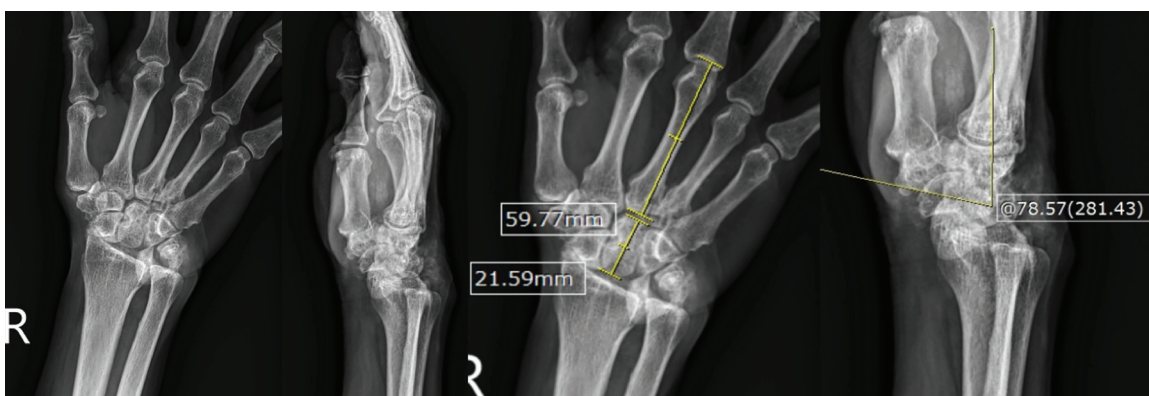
Radiograph, measurement of carpal height ratio, and radioscaphoid angle of the right wrist.
